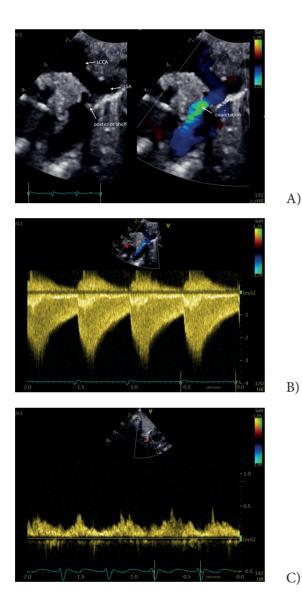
Echocardiographic hallmarks in a newborn with CoA and with a closed ductus arteriosus. A) Sagittal view of the aortic arch with and without colour flow Doppler. There is a short coarctation in the aortic isthmus with a posterior shelf. B) Continuous wave Doppler in descending aorta. There is an increased flow velocity in systole and a diastolic extension. C) Pulsed wave Doppler of the abdominal aorta showing blunted pulsatility and diastolic extension. LCCA: left common carotid artery, LSA: left subclavian artery
